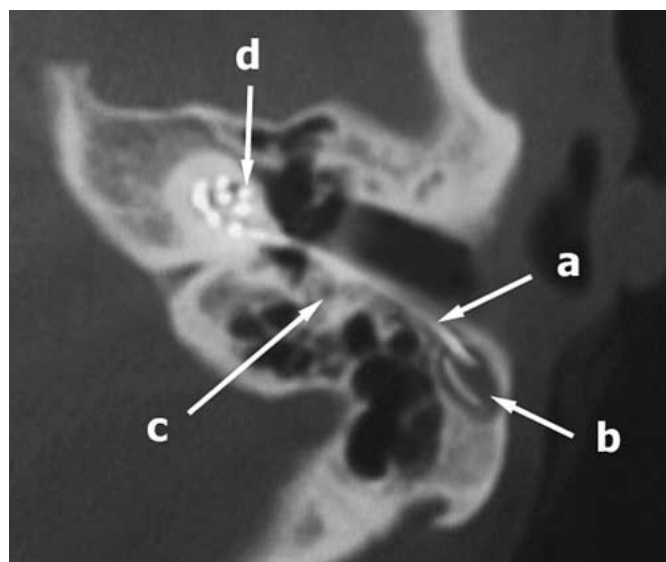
The postoperative situation on a CT scan image: (a) the electrode cable runs in the direct tunnel, which is very superficial; (b) the suprameatal hollow accommodates the excess of the electrode; (c) the facial canal is far from the tunnel, and (d) real deep insertion with a Med-El electrode. The first contact approaches the apex. Notice the undisturbed middle ear and mastoid air cell system anatomy and function.
